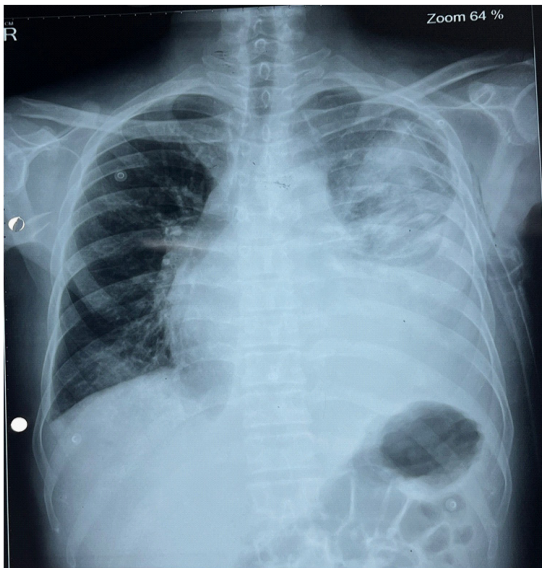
Chest X-ray PA view showing cardiomegaly with enlarged cardiothoracic ratio. The left upper lobe shows fibrotic changes post-pulmonary tuberculosis.
